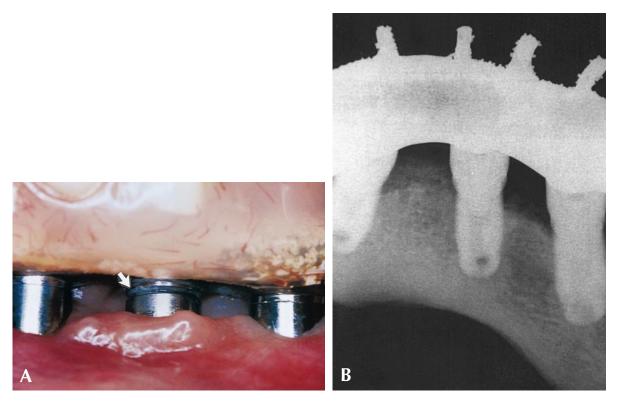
A, Clinical view of framework misfit (*arrow*). B, Because of difficult radiographic access from high floor of month, radiograph failed to show misfit apparent in A.
